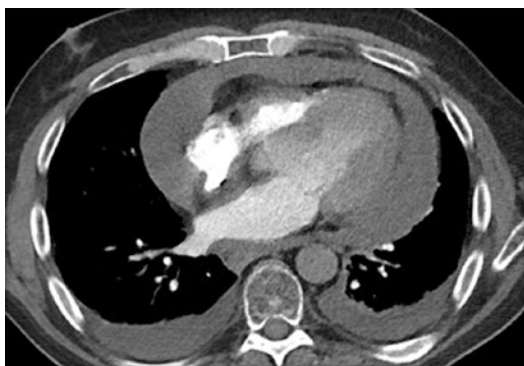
Large pericardial effusion and moderate bilateral pleural effusions. An echocardiogram should be ordered to exclude tamponade
